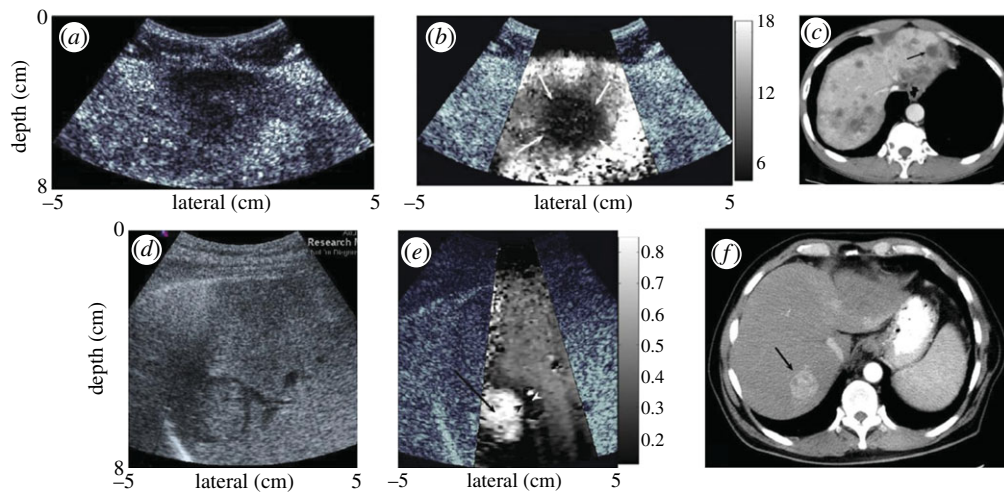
The top row of images shows a metastatic melanoma mass in an otherwise healthy liver background. The mass appears as a hypoechoic region in the B-mode image (a); in the corresponding ARFI image (b), the malignant mass does not displace as much as the background liver tissue and can be interpreted to be stiffer than the liver tissue. This mass is also identified as a region of reduced opacity on the corresponding computed tomographic (CT) image, indicated with an arrow (c). The images in the bottom row show B-mode (d) and ARFI displacement (e) images of a hepatocellular carcinoma in a fibrotic liver. In the ARFI image, the mass appears more compliant (i.e. displaces more) than the stiffer, diseased liver tissue. The corresponding CT image for this hepatocellular carcinoma is shown in (f), with the lesion indicated with an arrow. The greyscale bars in the ARFI images represent displacement in micrometres. (Reproduced with permission from *Physics in Medicine and Biology* [32]).
